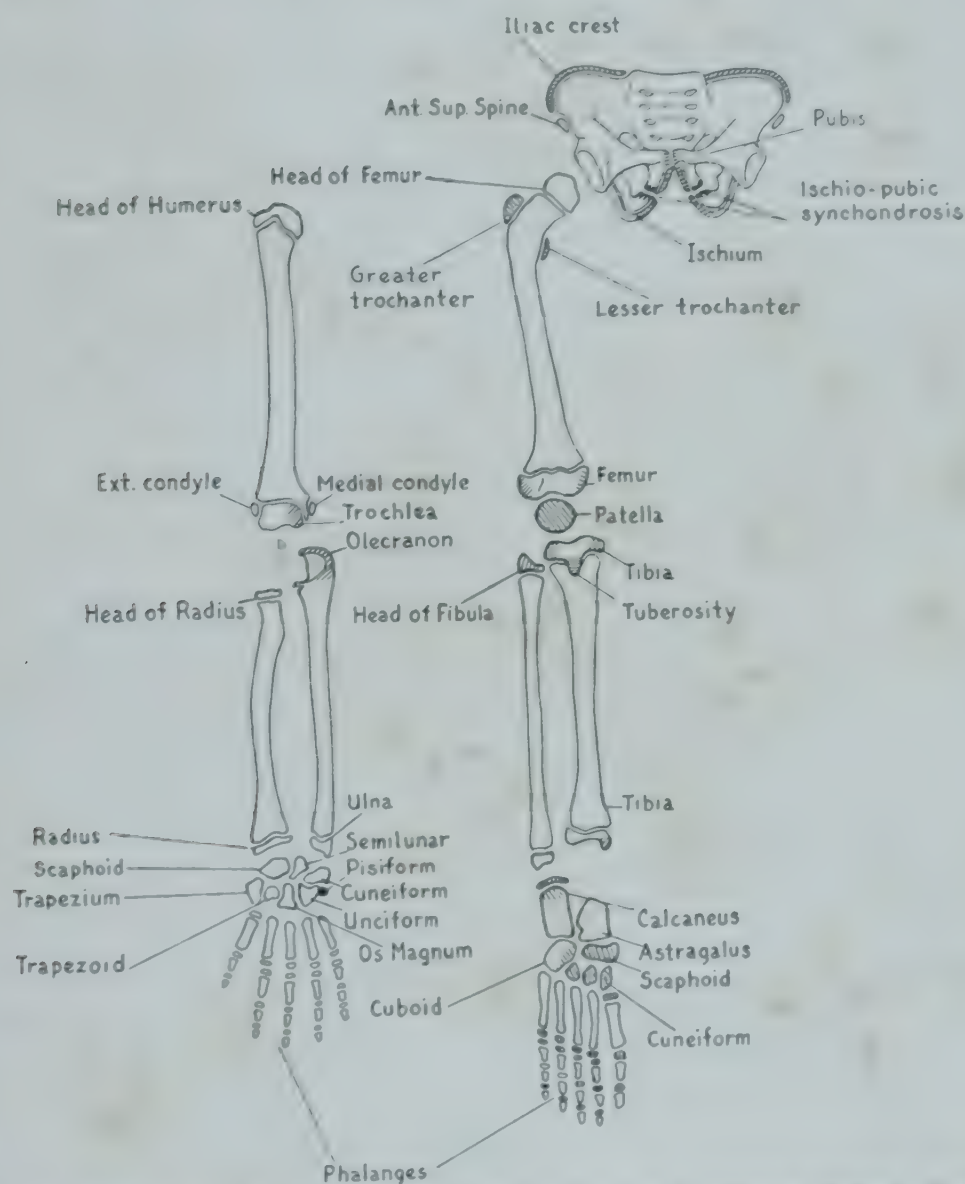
Sites of normal irregular mineralization in the growing skeleton. Sites of physiologic irregular mineralization are shaded. (Caffey, J.: *Pediatric X-Ray Diagnosis*, Year Book Publishers, Inc.)
